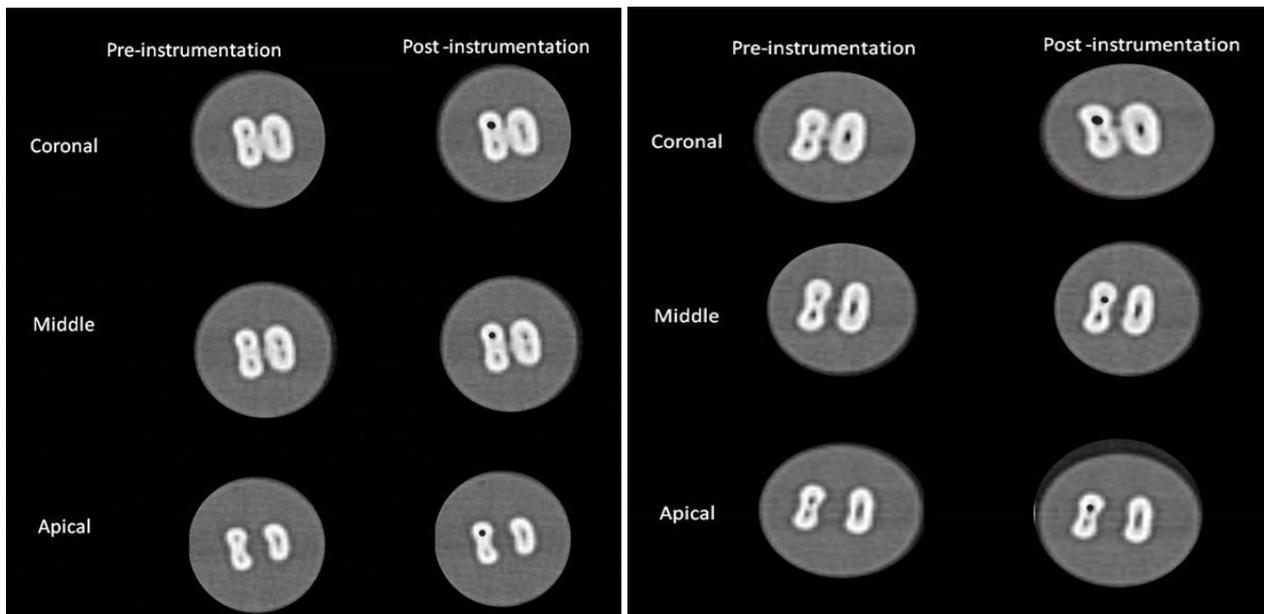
CT scan images before and after instrumentation with Hyflex CM (left) and WaveOne (right).
